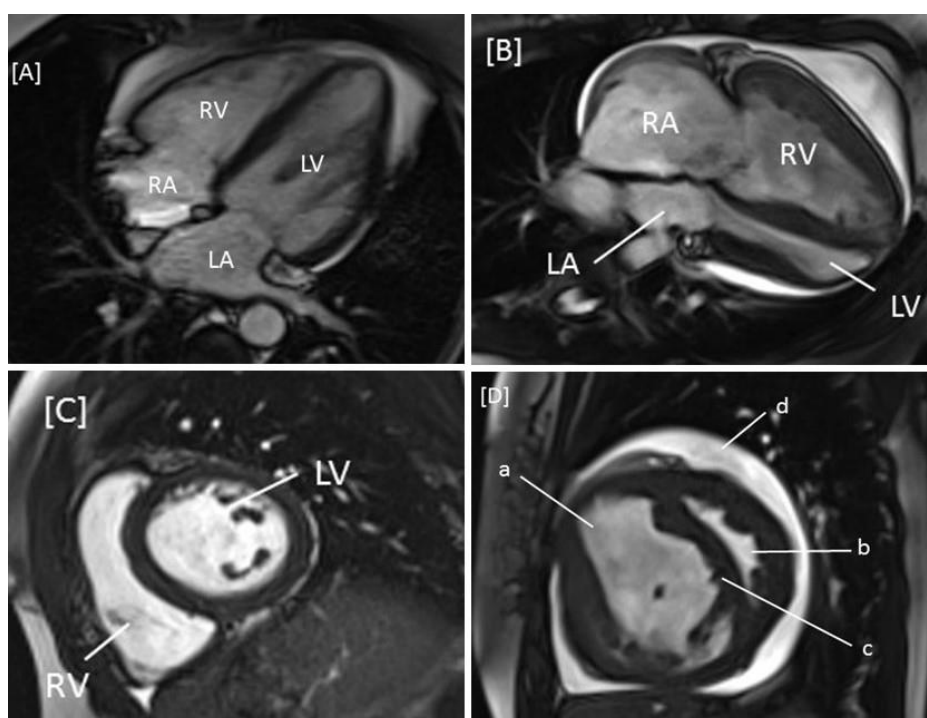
Cardiac MRI images of a normal subject in comparison to patient with pulmonary arterial hypertension.
